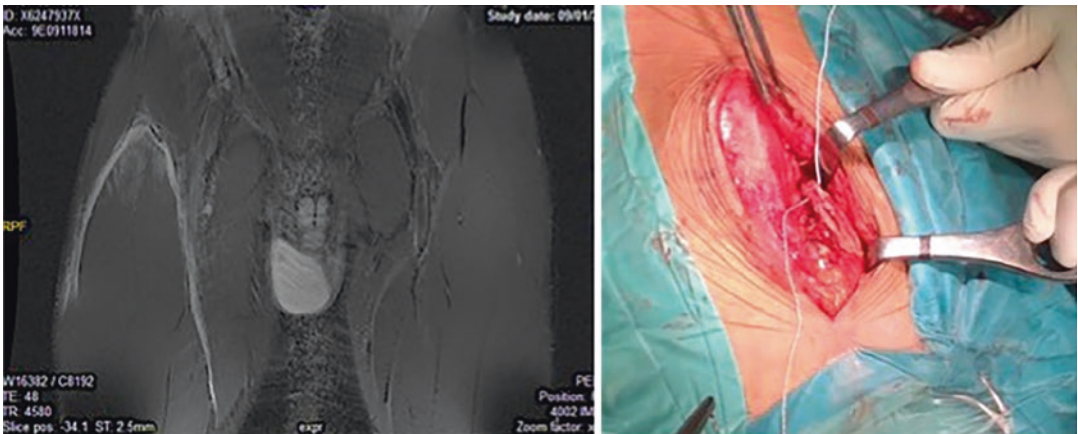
Coronal MRI T2-weighted image. Intraoperative view of rectus femoris tendon secured with No. 2 FiberWire (Arthrex Inc., Naples, Florida), in professional football player
